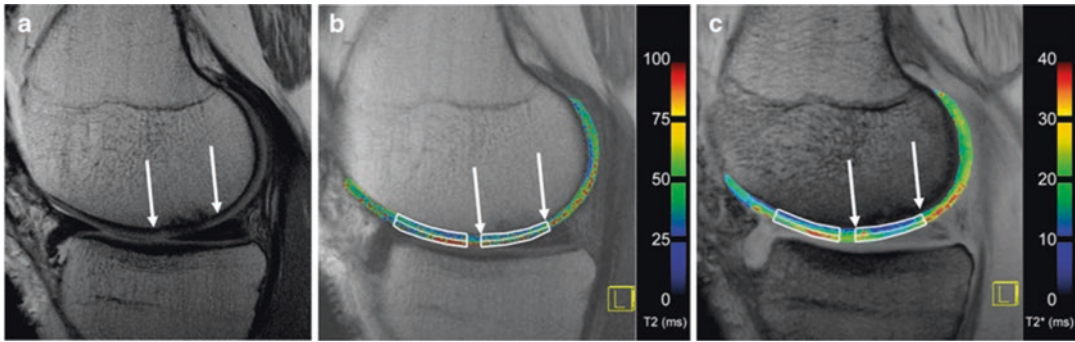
MRI of the medial femoral condyle of a patient obtained at 60 months after matrix-associated chondrocyte transplantation. MR images were obtained using morphological proton density Turbo Spin Echo (PD-TSE) sequence (a), matched quantitative T2 map (b), and T2* (c) maps. Arrows mark the area of cartilage repair. The rectangular regions of interest (ROIs), considering a possible zonal variation, provided information on the mean (full-thickness) as well as the deep and superficial aspects
